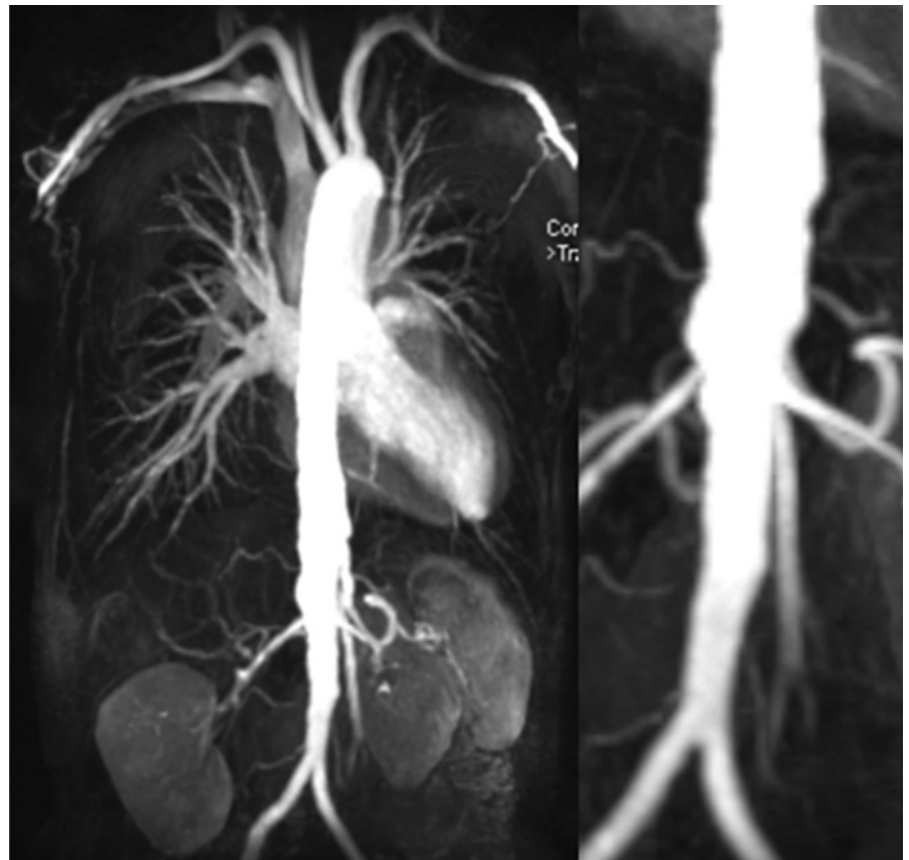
MRI angiography of aorta showing only stenoses of the descending aorta (probably due to atherosclerosis).
